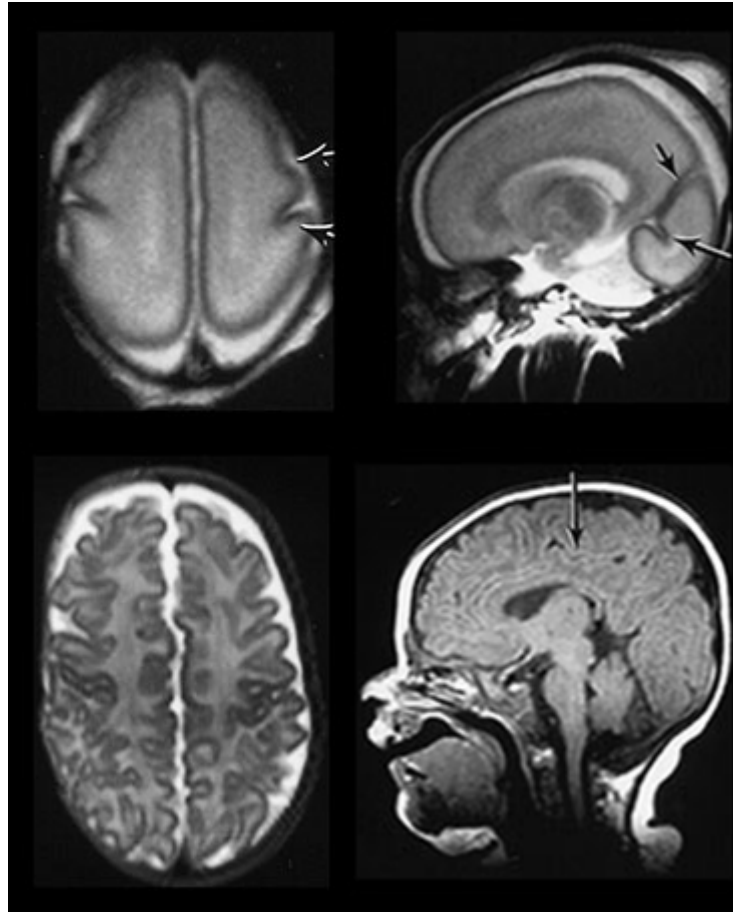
Magnetic resonance imaging (MRI) picture of cortical folding at 26 weeks GA (above) and term (below) in the transverse (left) and sagittal (right) planes. Taken from [3].
